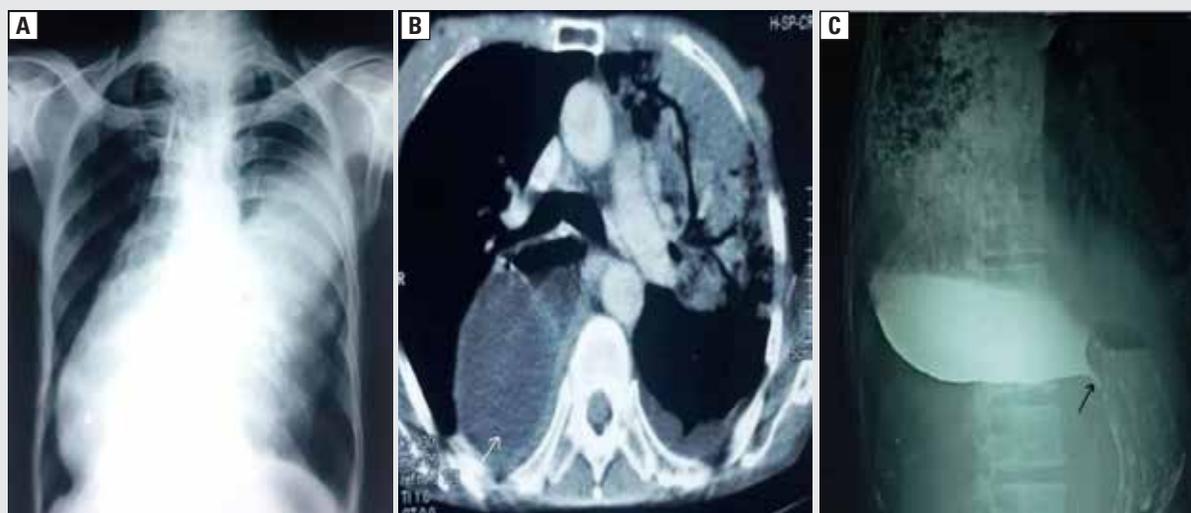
A. Chest radiograph showing left upper and mid zone homogenous opacity with a gross widening of the mediastinum; B. Mediastinal window of CT of the thorax showing the grossly dilated esophagus with air fluid level, left upper lobe consolidation with minimal left pleural effusion; C. Barium study showing the dilatated esophagus with tapering at gastroesophageal junction
